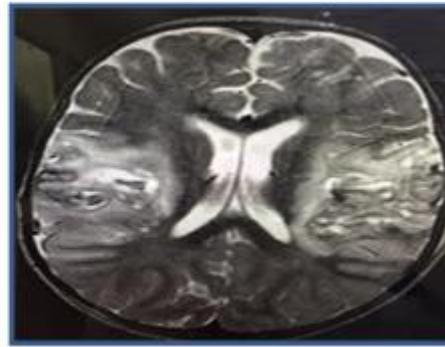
MRI brain showed
